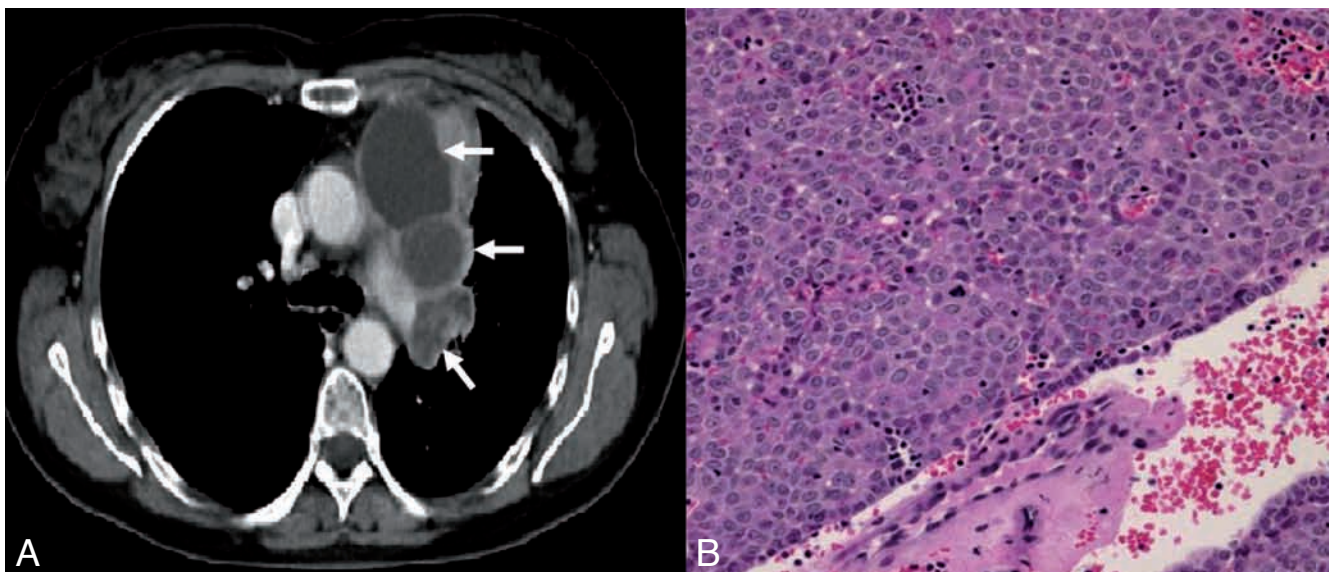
Thymic carcinoma. A) A 61-year-old woman consulted the pulmonary specialist because of cough and hoarseness. CT showed a large suspicious process above the left hilus in the anterior mediastinum. The mass contained central necrotic and cystic areas (arrow). Laterally there is a tissue board and the medial border of the process is inseparable of the ascending aorta. B) APE: Epithelial cells with nuclear atypia and many mitosis: good to moderated differentiated squamous cell carcinoma of the thymus (20).
